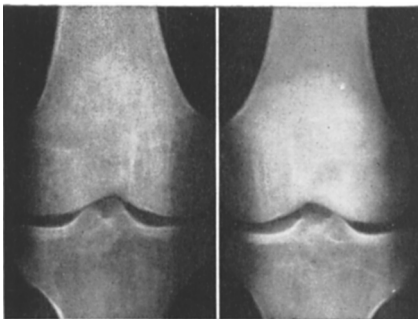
Radiograph of the knees of a patient who had a five-week-old fracture of his right tibia (Case I-5). A slight loss of density was observed in the knee region of the fractured leg but the accretion rate in this knee did not differ from that in the other knee (see Fig. 6 which shows the activity values in this patient).
